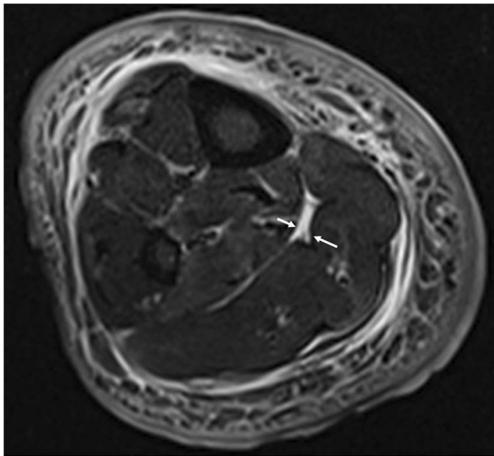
A 52-year-old male with necrotizing fasciitis. Axial fat-suppressed T2-weighted image of the right lower leg demonstrates thickening of intermuscular deep fascia (arrows) without multi-compartmental involvement. The LRINEC score was 4, while the total score using the new scoring system was 5.5 (thickening of intermuscular deep fascia ≥ 3 mm [1.5 points] + multi-compartmental involvement [0 point] + LRINEC score [4 points]) with a predicted probability of 53.9% for necrotizing fasciitis. Note that although the LRINEC score was the same as that for the patient in Fig. 5, the total score using the new system was different
